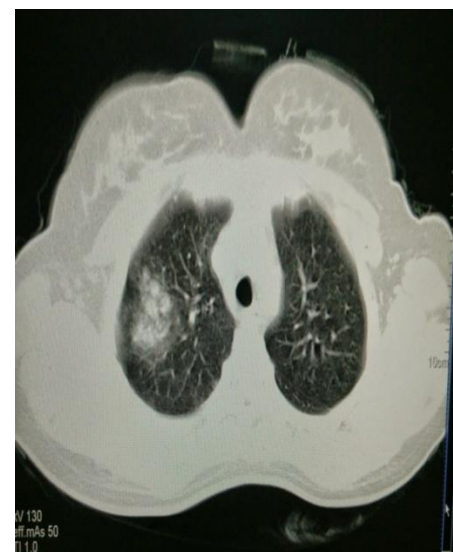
Chest radiograph (After Treatment of 10 days)
